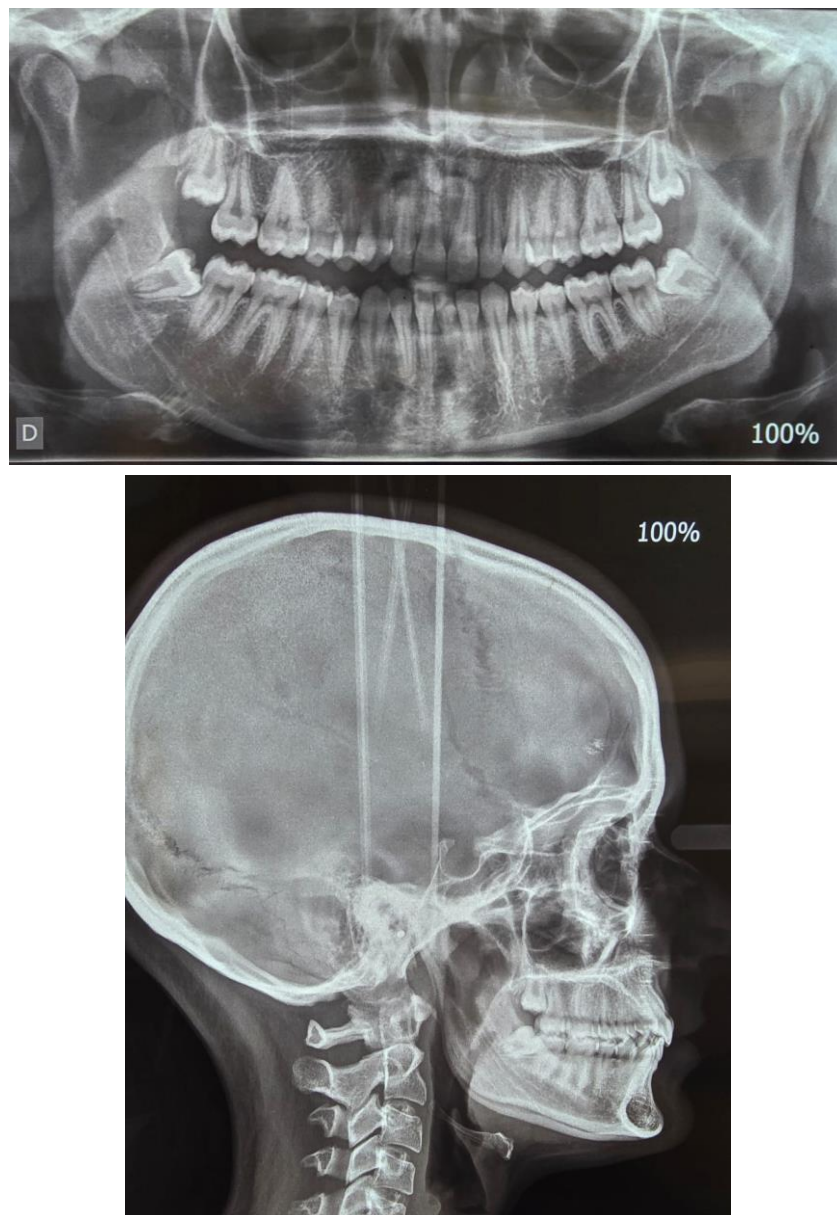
Cephalometric radiograph
